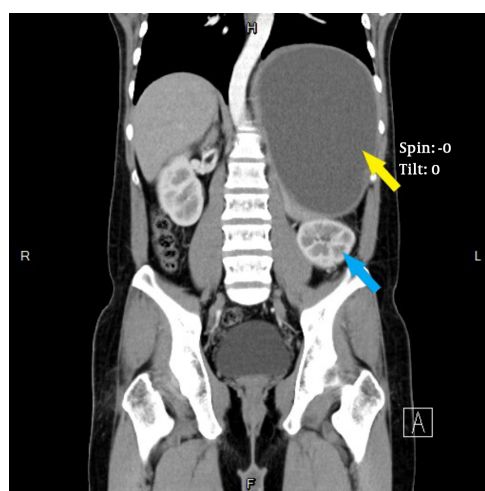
A massive cyst pushing the left-sided kidney downward, coronal view of contrast-enhanced computed tomography of the abdomen, yellow arrow: the cyst; blue arrow: the kidney
